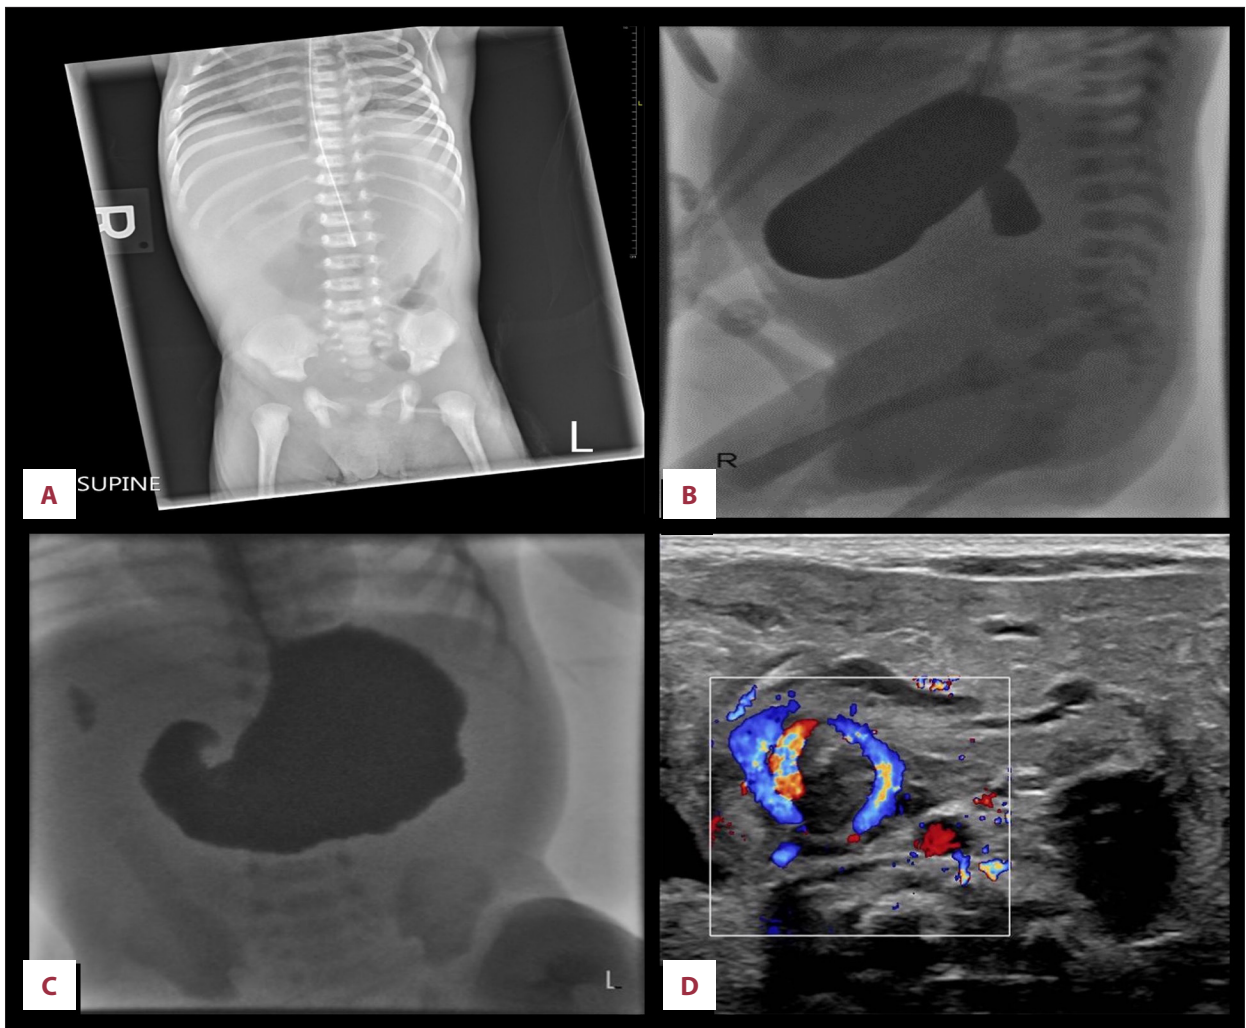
(A-D) Abdominal radiograph and upper-GI contrast study suggest a high-grade obstruction at the level of the proximal duodenum. US reveals reversal of superior mesenteric vessels.
